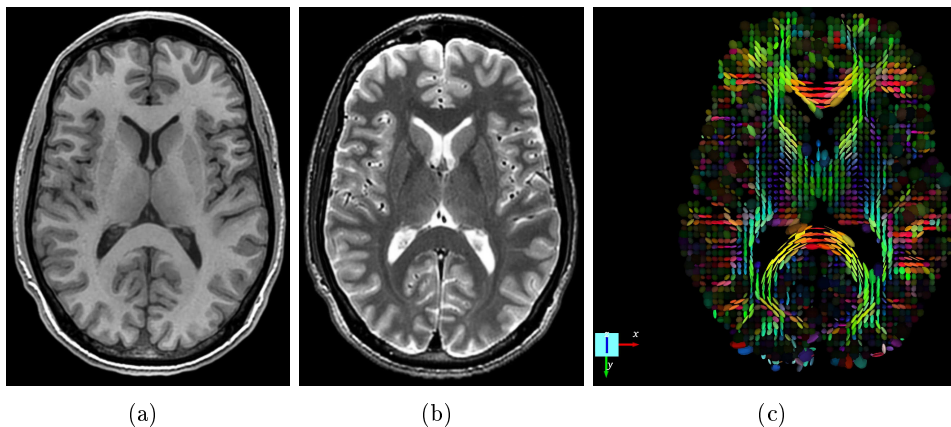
(a) An axial slice of a T1-weighted image of a healthy brain. (b) The same axial slice of the T2-weighted image of the same brain. We see that in T1-weighted images the fat tissue is enhanced while the water is not. On the other hand, in T2-weighted images the appearance of fat and water are inverse. This flexibility in MR imaging gives us the opportunity to have a very different appearance of the same brain in two different modalities. (c) An axial slice of a DT-MRI image of the same brain as shown in Figures (a) and (b). Each tensor is visualized as an ellipsoid and the image is subsampled for a clearer visualization. The colors of the ellipsoids represent the direction of their major axis.
